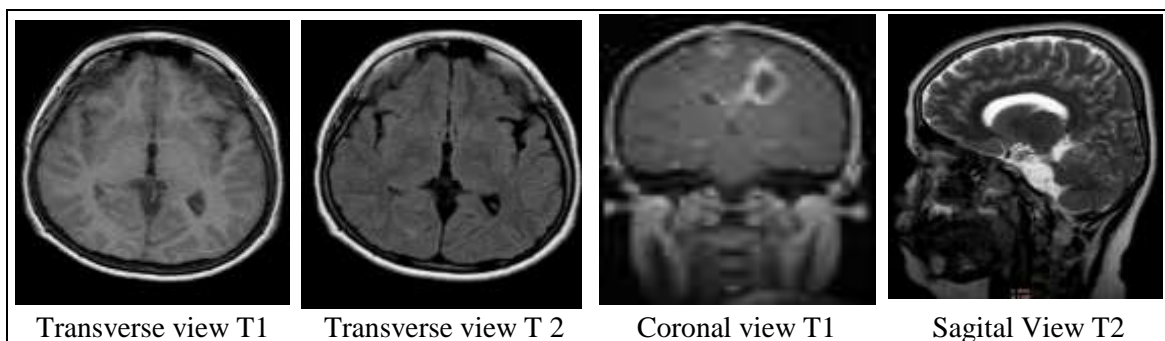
Examples of MRI weighted images
